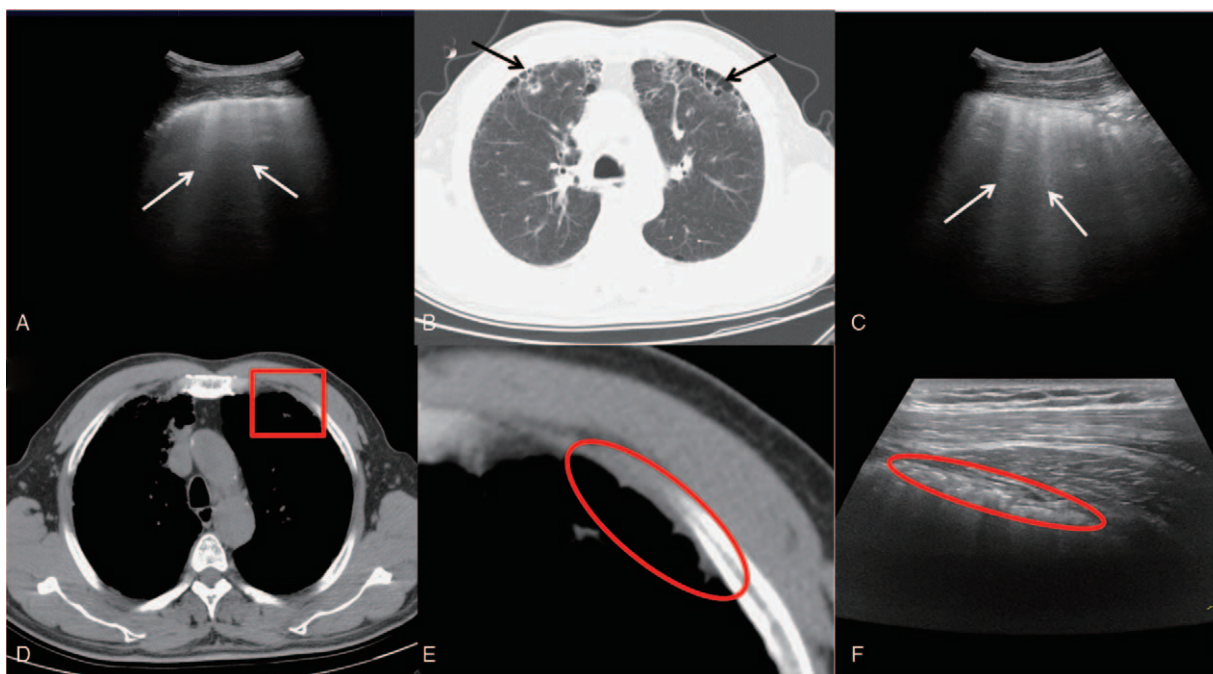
Lung ultrasound signs of ILD. Traction bronchiectasis and cellular changes around the upper lung were found in the HRCT (Fig. 3B, black arrow), and the corresponding changes for LUS presented as numerous B lines (Fig. 3A, 3C, white arrow), as obtained using a low-frequency probe. The HRCT longitudinal window of the above patient suggested a thickening of the left pleural pleura (Fig. 3D, 3E, red ellipse), and the corresponding changes for LUS presented as the thickened and irregularly fragmented pleural line (Fig. 3F, red ellipse), as obtained using a high-frequency probe.
